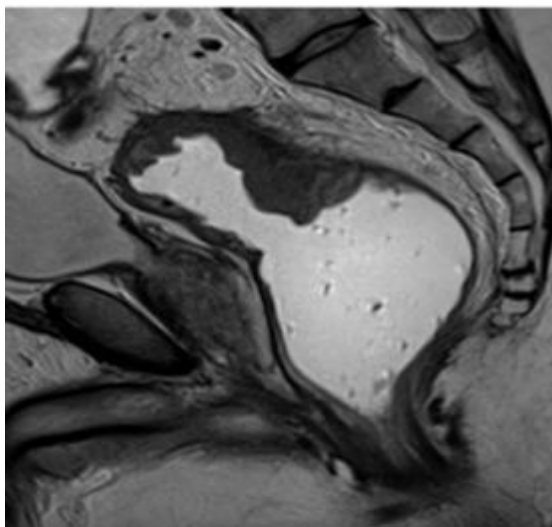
MRI T2W sagittal images showing a semi-annular morphology
